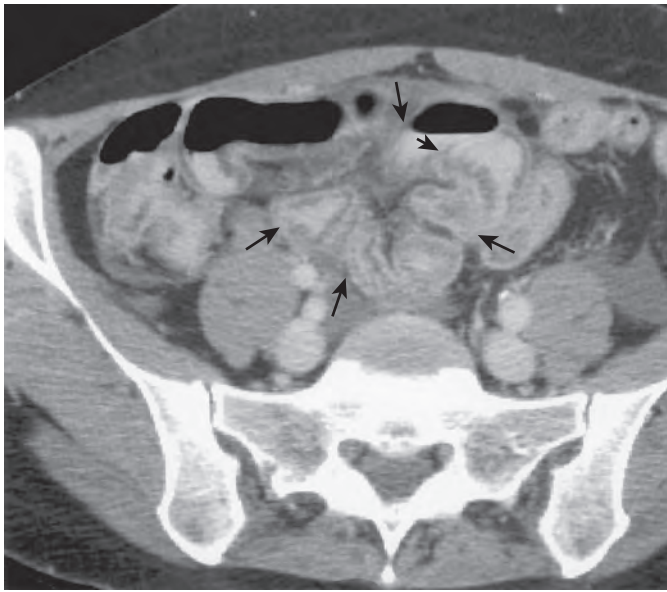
Ileal endometriosis. Axial CT through the pelvis shows ileal loops (long arrows) pulled toward the mesentery with associated tethering of folds (small arrow). The submucosa has slightly low attenuation.
